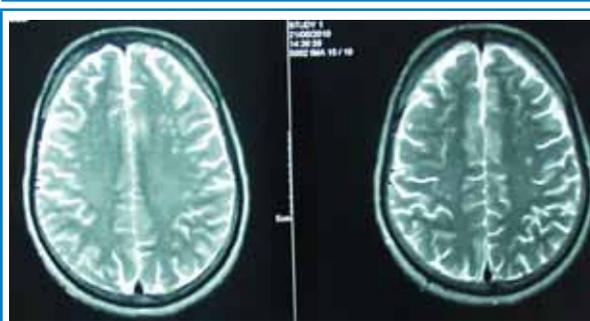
Foci of demyelination on MR images
